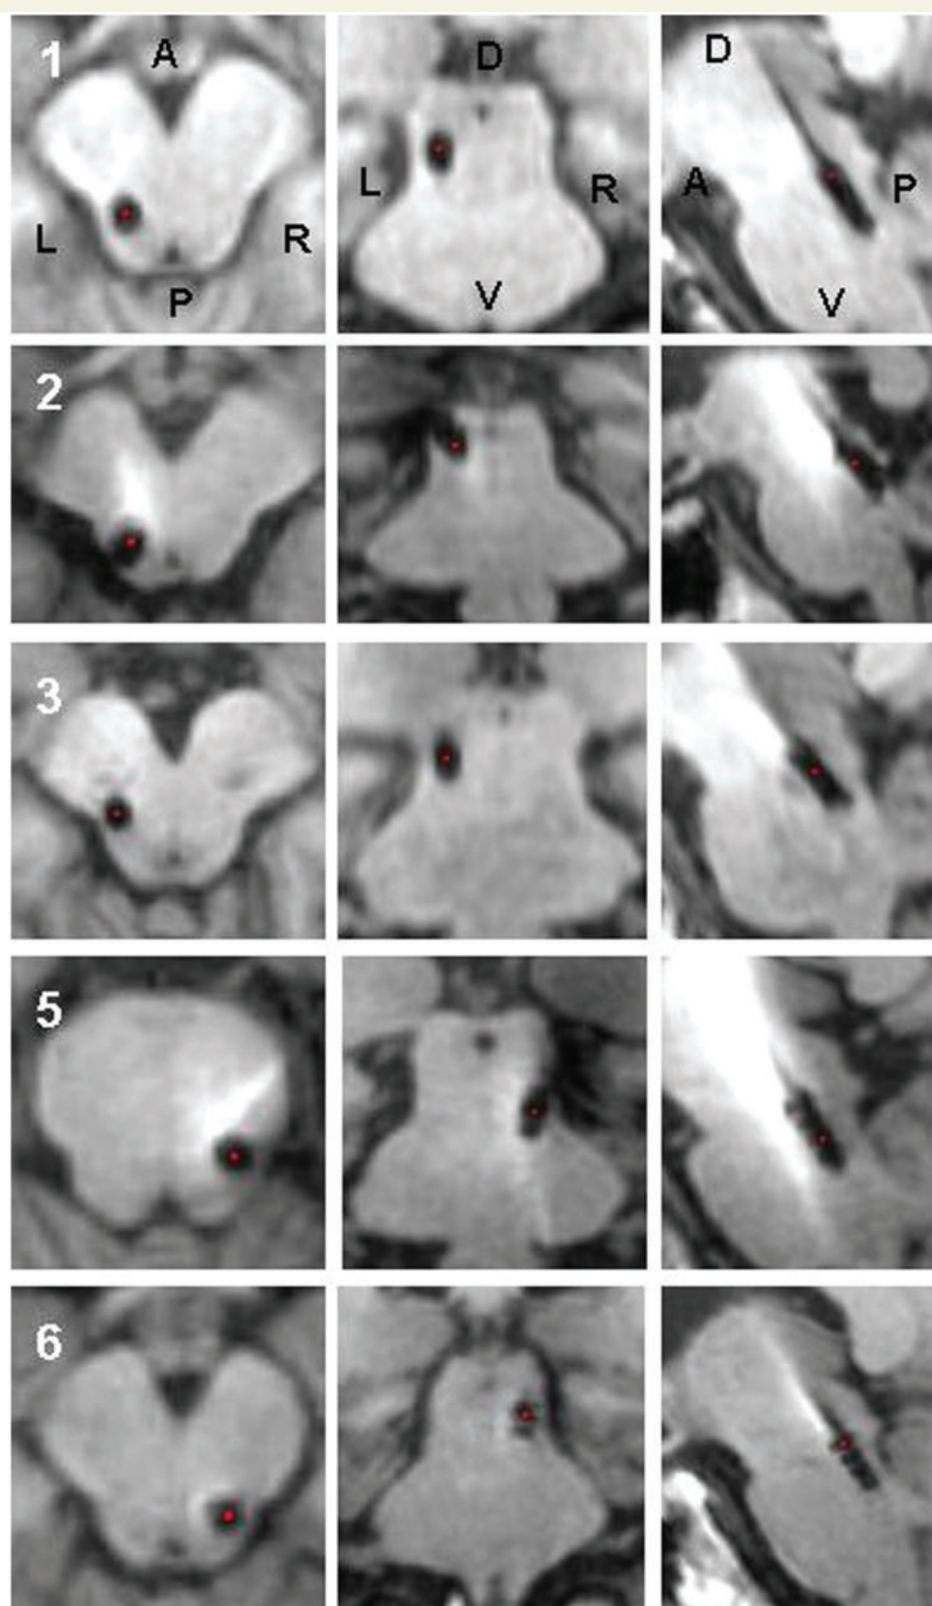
Location of the electrodes in patients treated with PPN DBS. Axial (left), coronal (middle) and sagittal (right) MRI sections showing the placement of electrodes in our study. Red dots were placed over the centre of the contacts used as cathodes. Numbers in the left correspond to those assigned to each patient in the tables containing clinical data. A = anterior; P = posterior; L = left; R = right; D = dorsal; V = ventral. Patient 4 only had CT imaging and therefore was not included.
